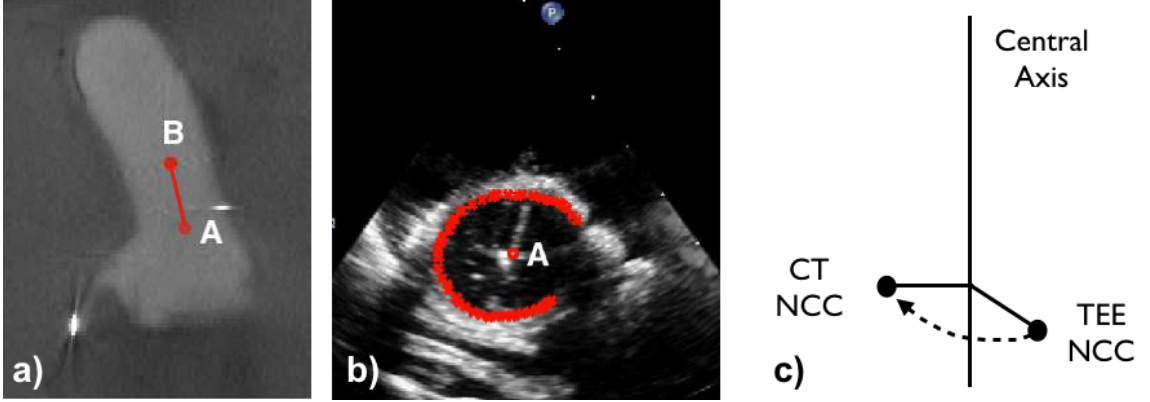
ICP Initialization. (a) Selection of the central axis in CT. (b) Selection of the central axis in TEE. (c) Alignment of the non-coronary cusp measured in the CT image and the TEE image.
